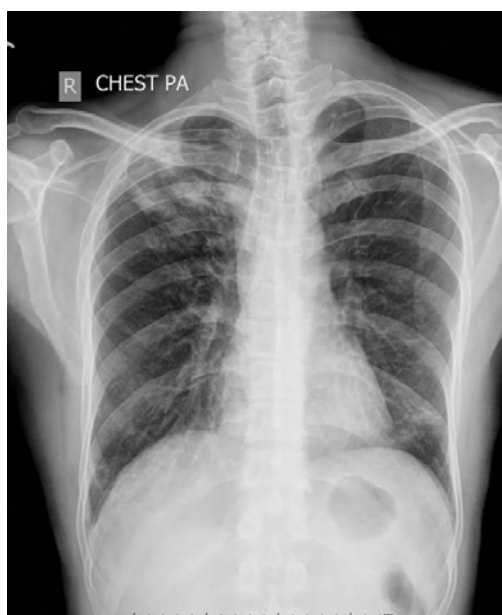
Frontal chest radiograph.
